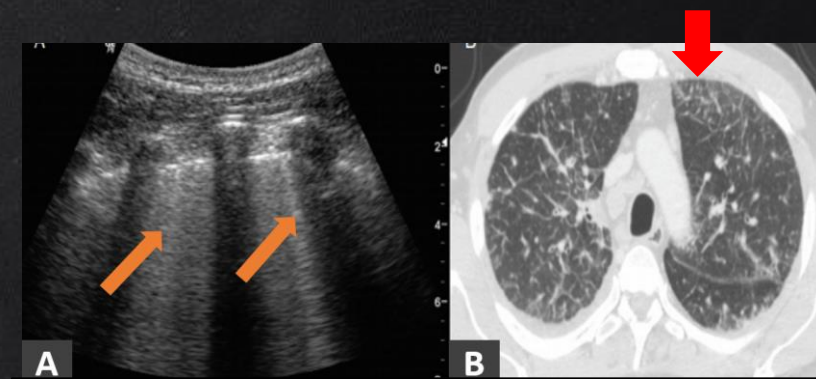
75-year-old man with congestive cardiac failure. Lung ultrasound demonstrates multiple vertical (A) - (orange arrow) confluent streak-like hyperechogenic artefacts are visible around the left lung apex, arising from the pleural surface, which correspond to B lines. There is the lung CT correlation showing interlobular septal thickening (B) - (red arrow) in the same location.
